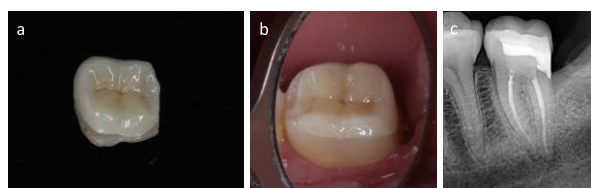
a) Lithium disilicate onlay b) Results of try in c) evaluation of results of try in by periapical radiography.
